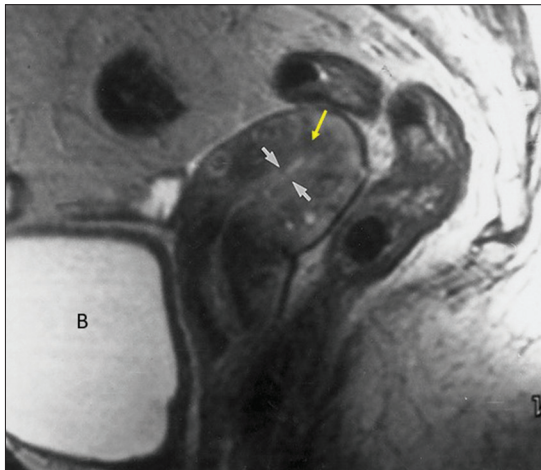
Normal postmenopausal endometrium: Sagittal T2-weighted magnetic resonance image obtained in a 60-year-old female 3 years after menopause reveals a small uterus with a normal, thin (<4-mm), hyperintense endometrium (solid arrows) and barely perceptible hypointense junction zone (yellow arrow). The zonal anatomy is best visualized during the reproductive years and may be poorly depicted or absent in prepubertal and postmenopausal women.^[5] Note that the uterine corpus has undergone some atrophy and is only slightly bulkier than the cervix. In late menopause, the uterine corpus is smaller than the cervix, and the uterine zonal anatomy may be difficult to appreciate. B = Bladder
